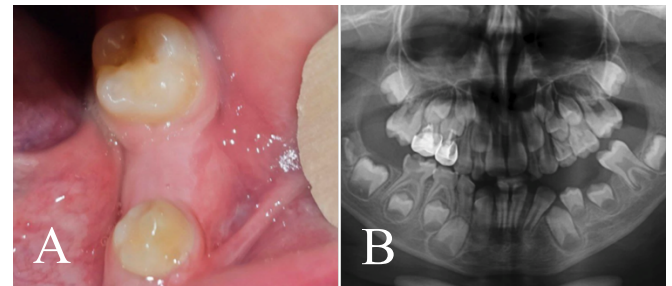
(A) Intraoral view after 16 months of follow-up showing satisfactory healing; (B) cropped panoramic radiograph demonstrating bone healing and eruption development of the underlying permanent teeth.
